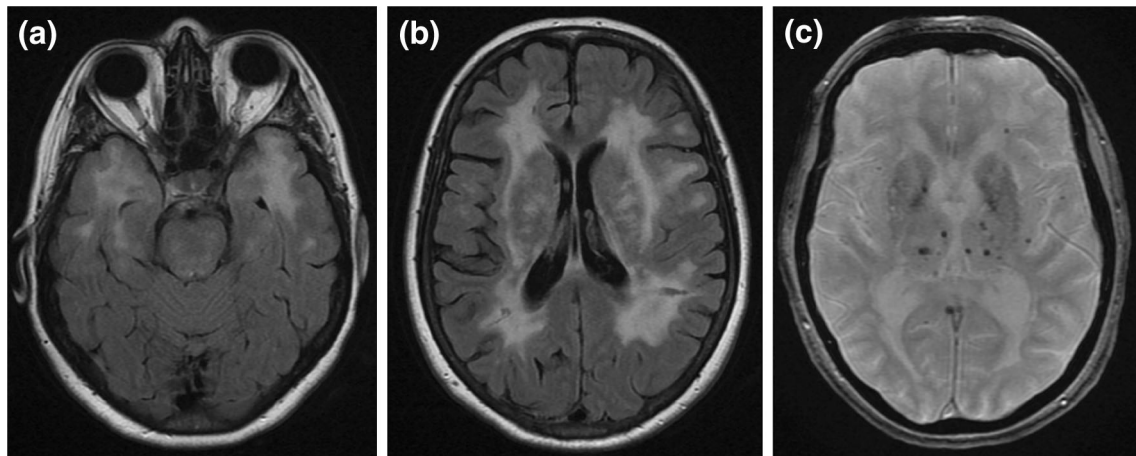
MRI appearances of CADASIL. White matter hyperintensities involving the anterior temporal pole (a) and external capsule (b) are seen on T2/FLAIR MRI sequences and subcortical cerebral
